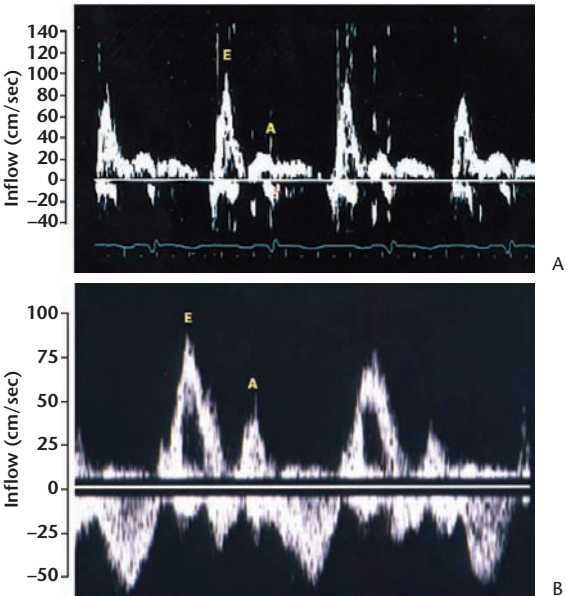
Doppler echocardiography of the left ventricular inflow in a patient with restrictive cardiomyopathy secondary to amyloidosis (A), and a normal Doppler signal in a patient without cardiac disease (B). Reprinted with permission from Kushwaha SS et al.<sup>49</sup>
